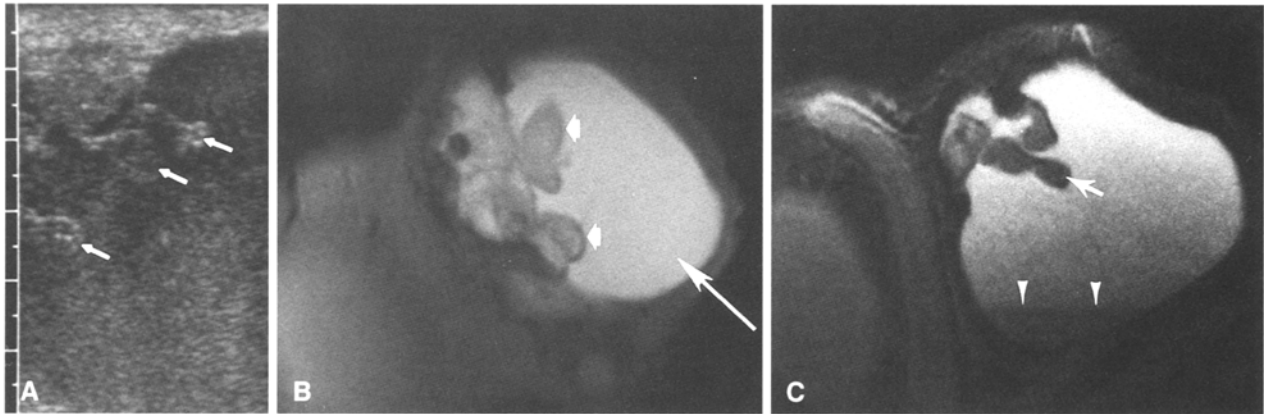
Ultrasound and MRI fibrous pseudotumor of the tunica vaginalis testes. A Transverse ultrasound image of the left scrotal wall (testicle not on image), demonstrating lobulated nodules projecting off the anterior wall (tunica vaginalis) into the echogenic fluid (white arrows). B Proton-density weighted (TR 2000/TE 20) coronal image
